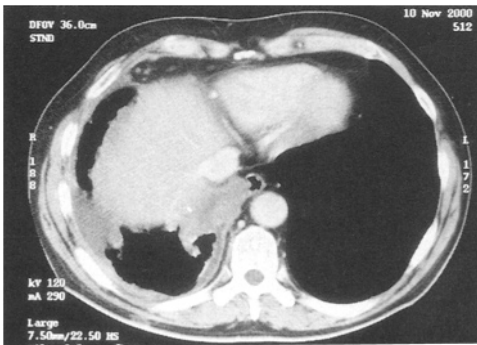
CT scan: 59 year old man with an epithelial mesothelioma. There is thickening of both parietal and visceral pleura with a small right pleural effusion. The tumour has directly invaded the mediastinum and a mass is seen adjacent to the right wall of the oesophagus
